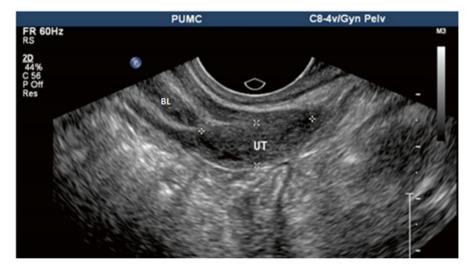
A 23-year-old patient with primary amenorrhea. Transrectal ultrasonography showing a hypoechoic structure behind bladder UT and BL, with the size of 2.0×0.8 cm
